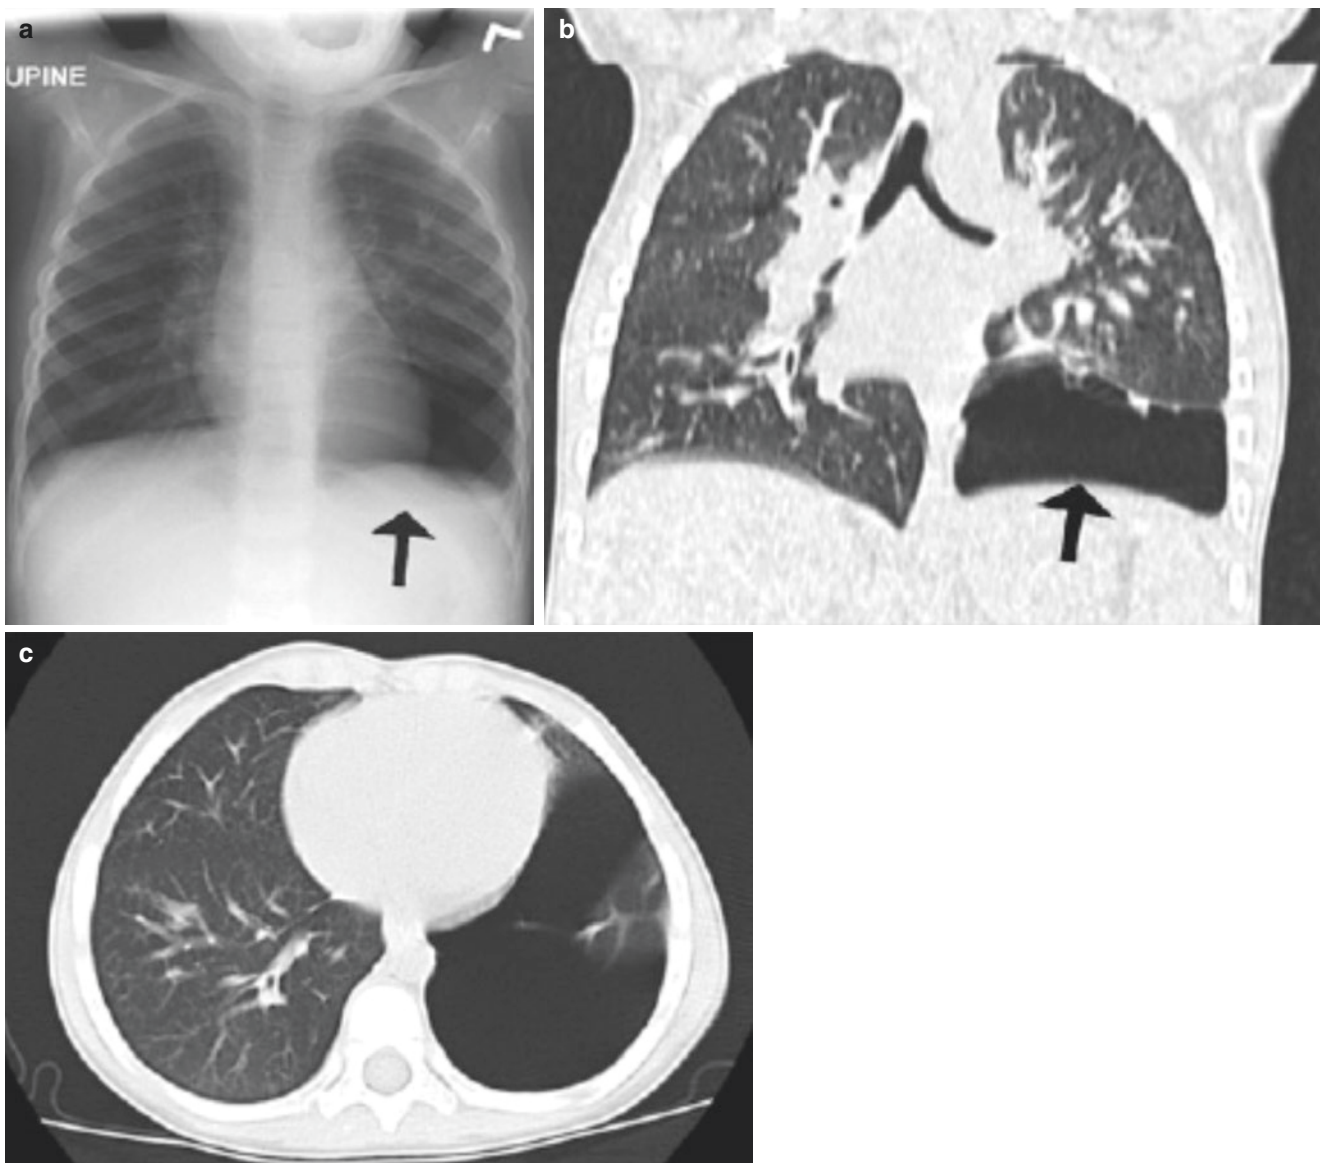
Pleuropulmonary blastoma (PPB) type 1 in a 3-year-old boy. (a) Frontal chest radiograph shows solitary lucent cyst (arrow) at left lower hemithorax. (b, c) Axial lung window and coronal reformation
